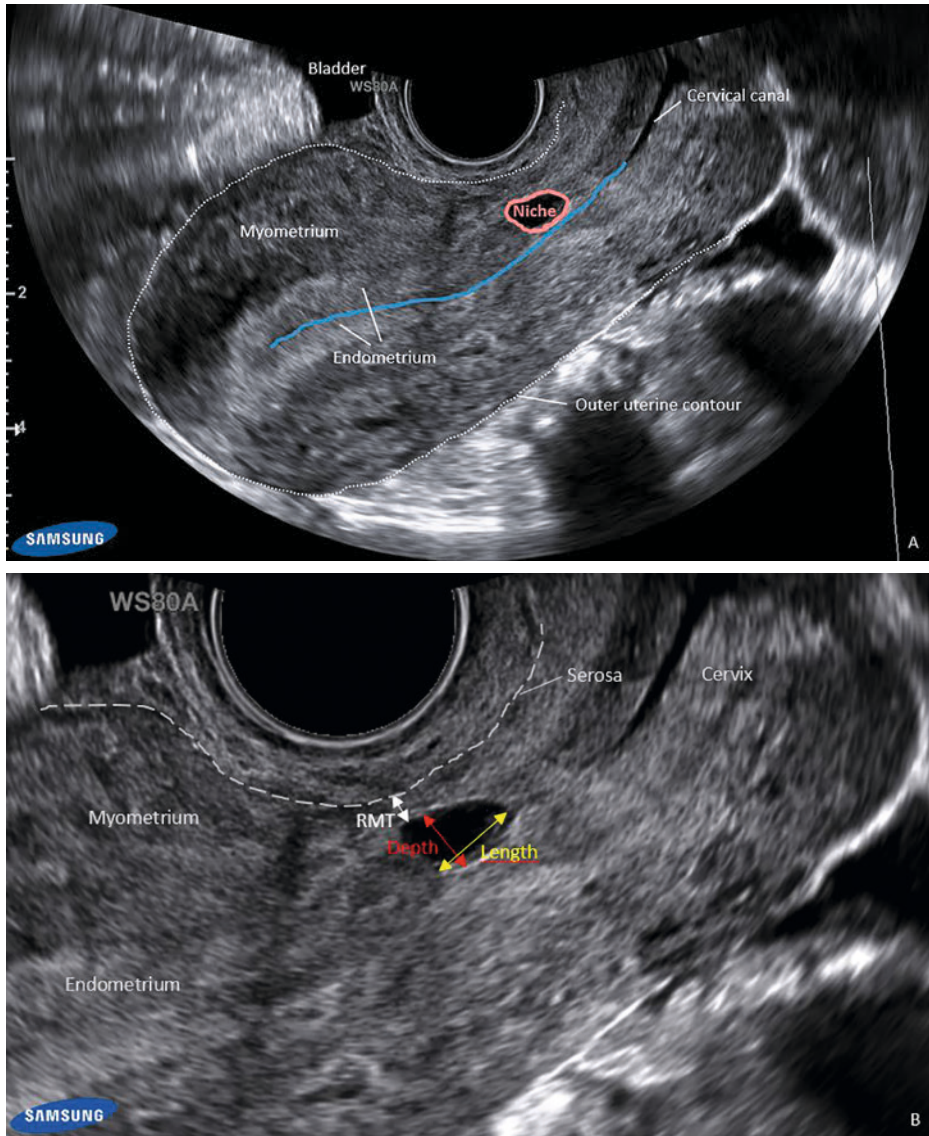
Example of uterine niche and its measurements in an anteverted uterus, according to Jordans *et al.* (2019) using transvaginal ultrasound.
